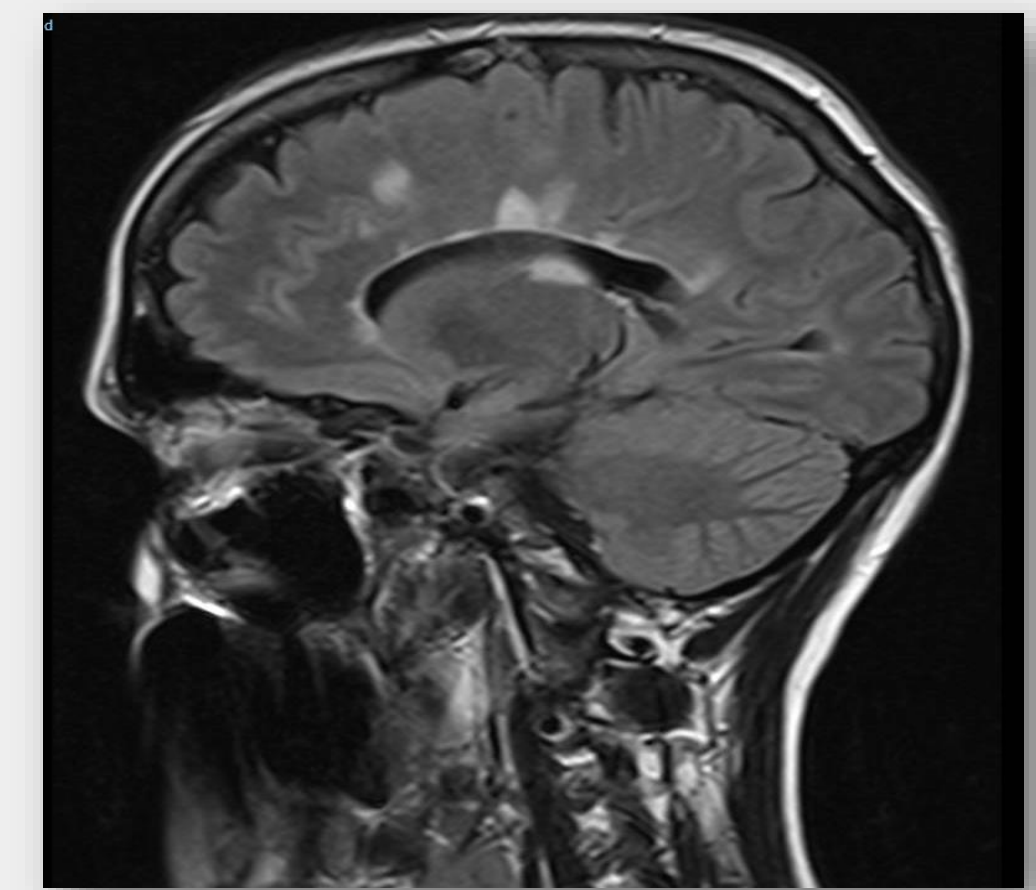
MRI, Sagittal T2 FLAIR brain, prior to fingolimod cessation.
